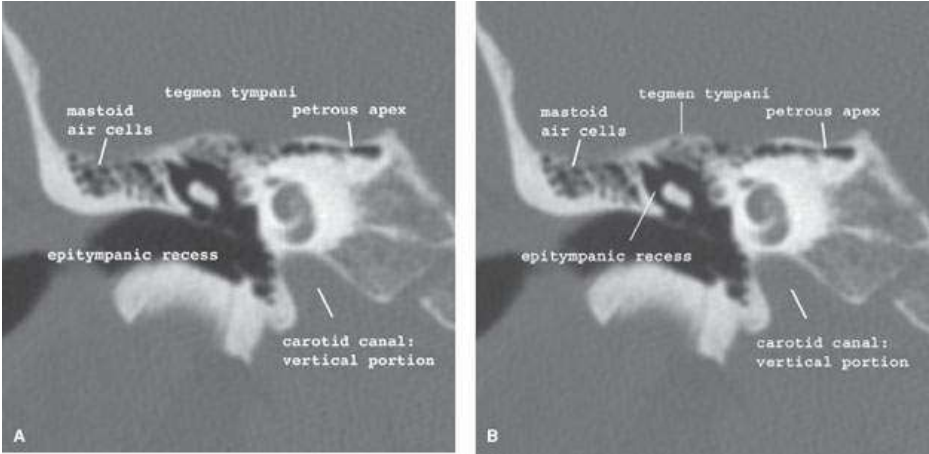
Coronal computed tomography images from anterior (A) to posterior (B). The bony roof of the mastoid consists of the tegmen tympani and the tegmen mastoideum. It is part of the middle cranial fossa and separates the middle ear and antrum from the temporal fossa.
